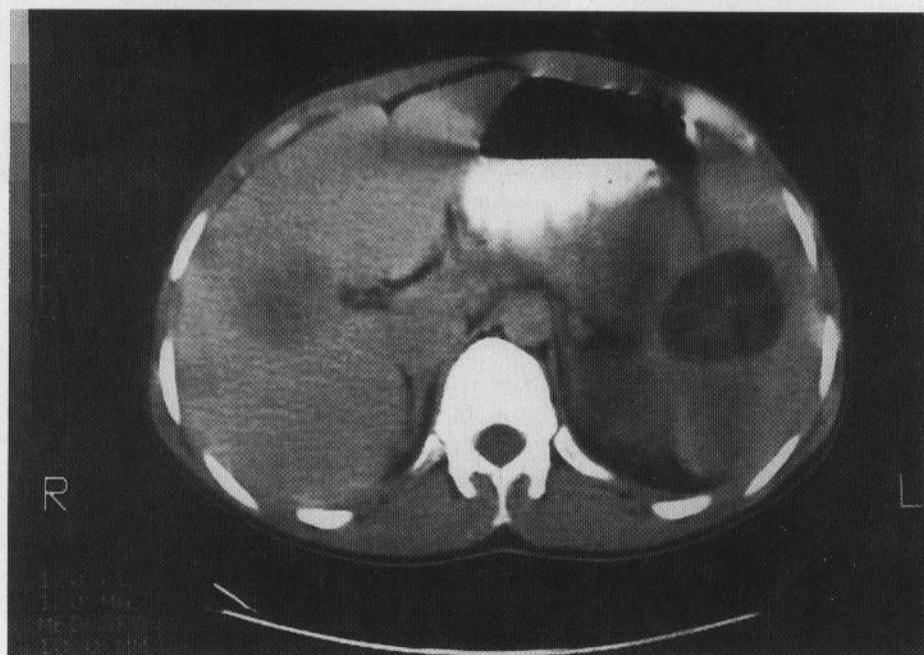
CT scan showing a hydatid cyst in the lower pole of the spleen.
